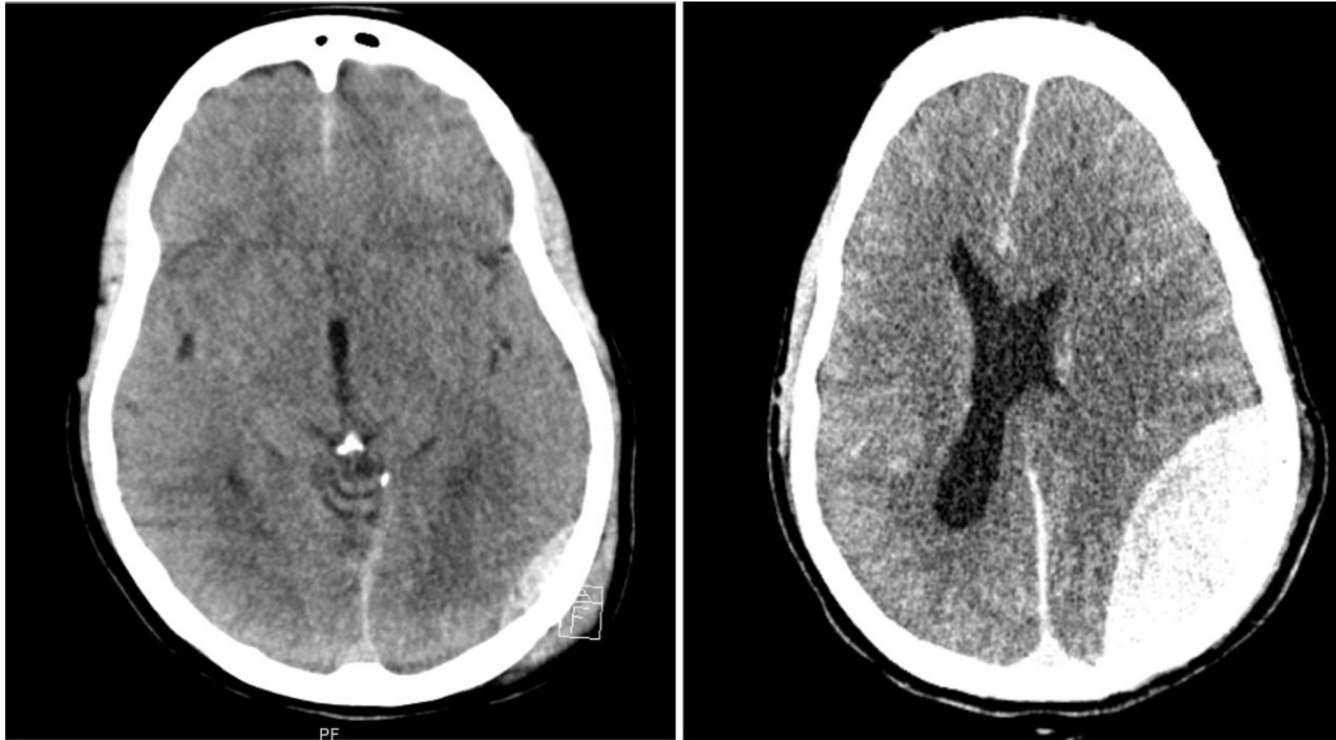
Plain CT head example axial sections at admission (left) and one hour post admission, coincident with clinical deterioration (right).
